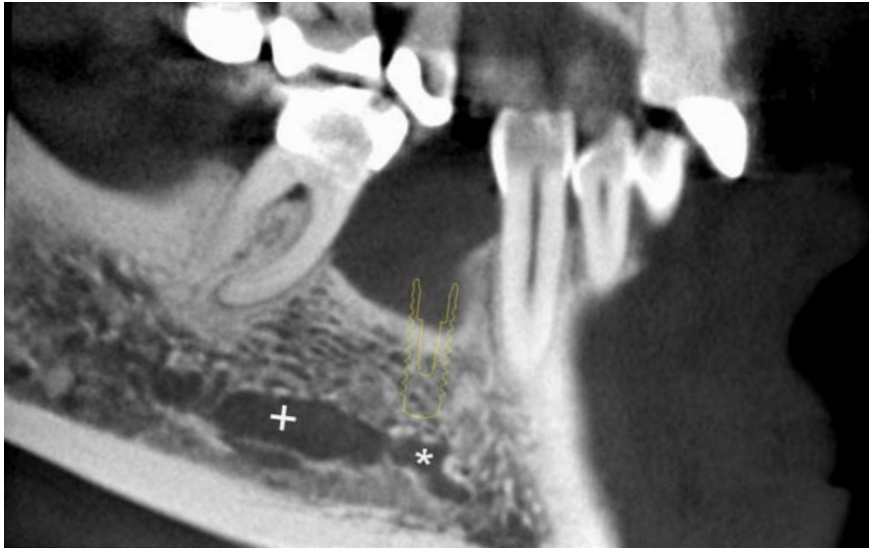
Sagittal CBCT image with mandibular (+) and incisive canal (*)
